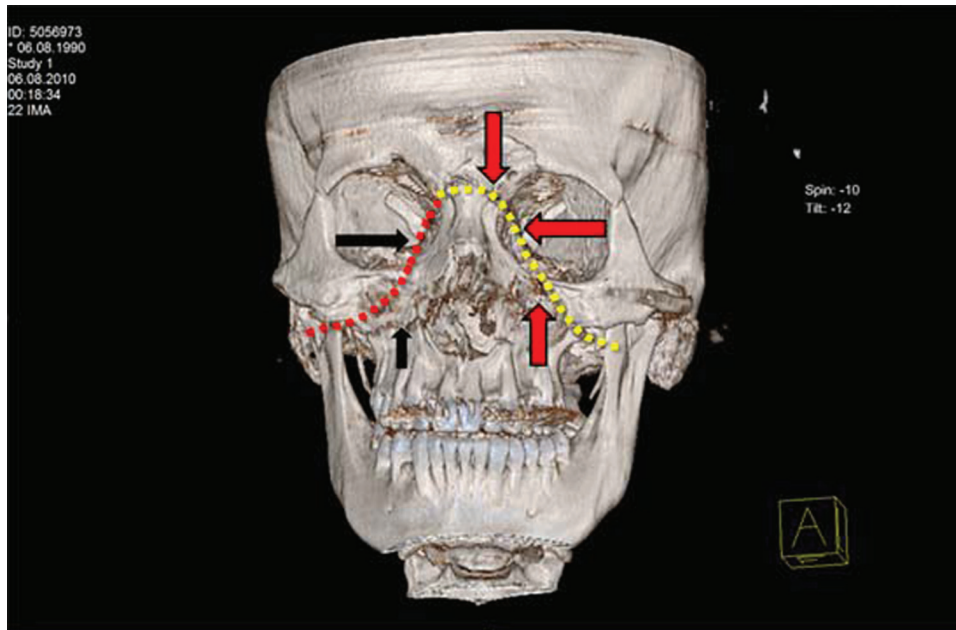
3D reconstructed CT of LeFort fracture. Yellow line: actual fracture lineage, Red line: full blown LeFort fracture lineage, Arrows: actual fractures.
